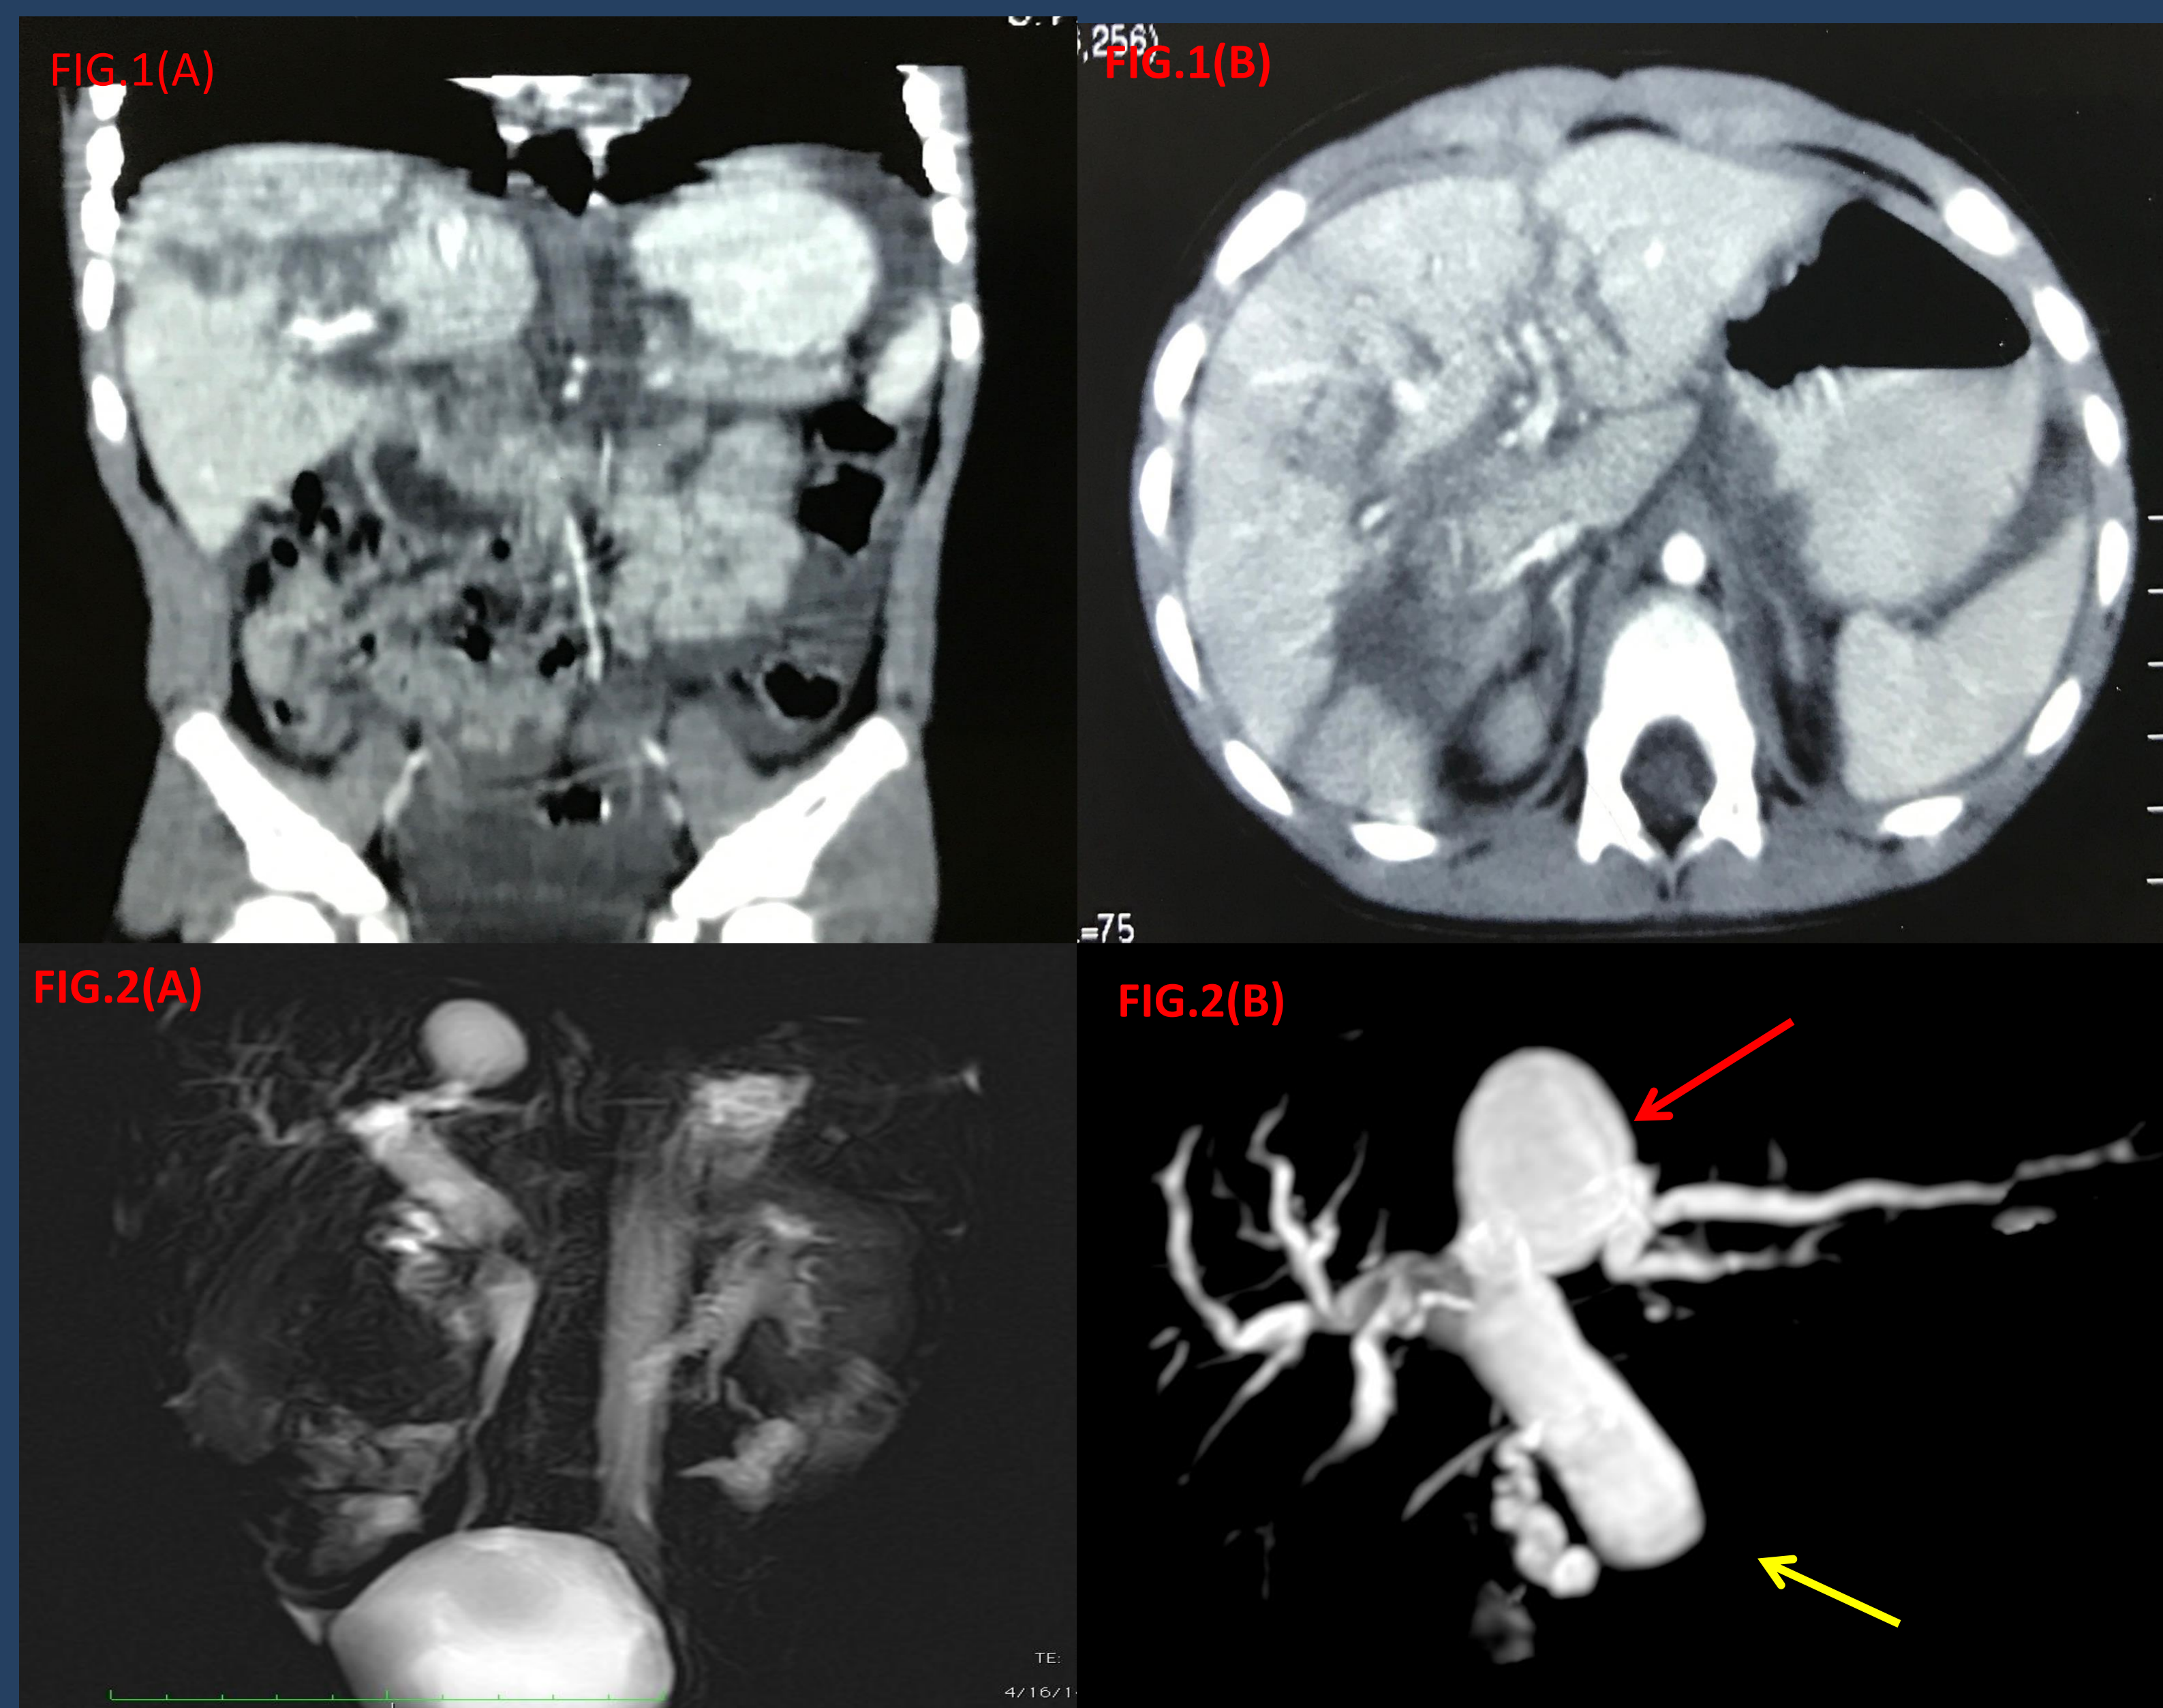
(a) & (b) : Contrast CT abdomen/pelvis showed grade IV liver injury with laceration at the segment IV .
